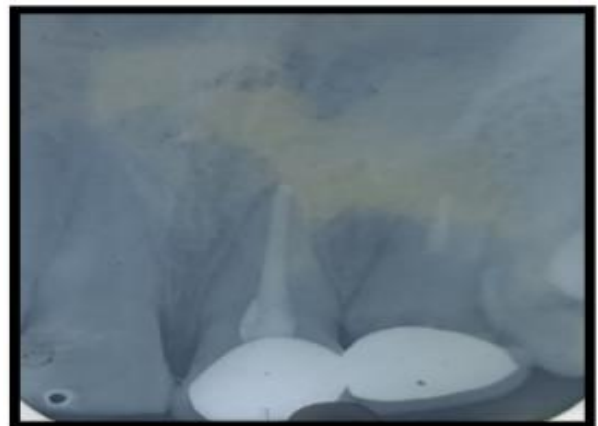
Three months follow up radiograph
